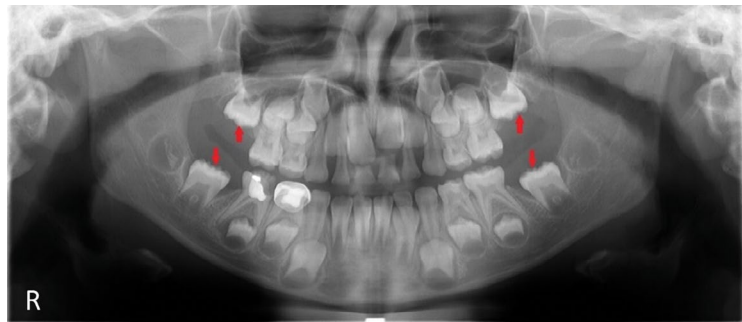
Panoramic radiograph of the eight-year-old patient showing the uneruption of all first permanent molars. Red arrows indicate the development of first permanent molars (16, 26, 36, 46)
